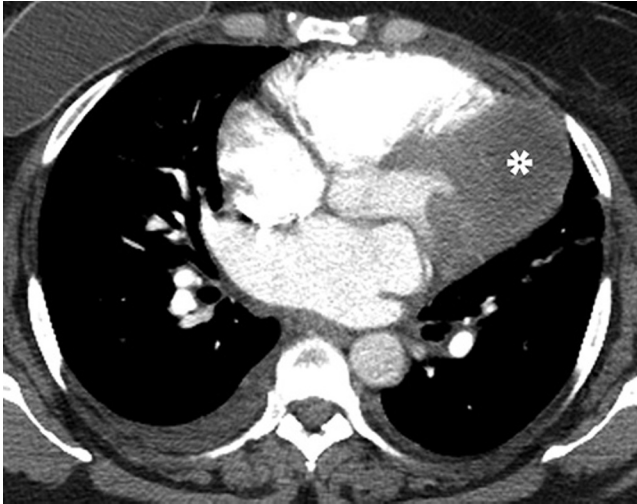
46-year-old female with spindle-cell sarcoma of the heart. Axial CT angiography image showed a large mass (asterisk) in the region of the left ventricle. Incidentally noted were also a small right pleural effusion and a right breast implant.
